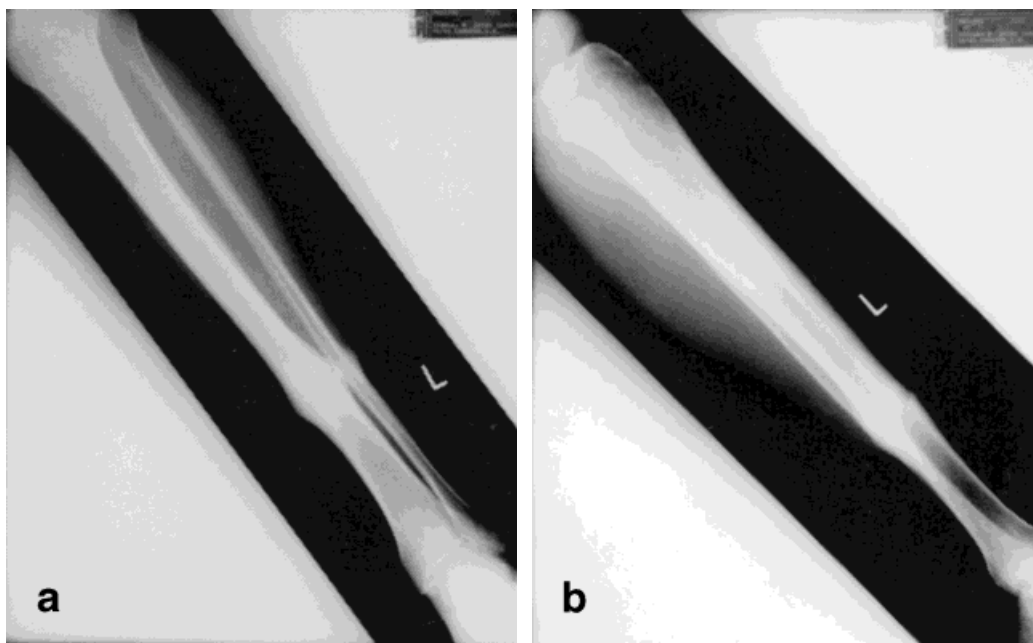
Single tibial fracture with double fibular fracture. These radiographs were taken more than 4 months postinjury and the fracture lines are still visible. a: Anterior view. b: Lateral view.
